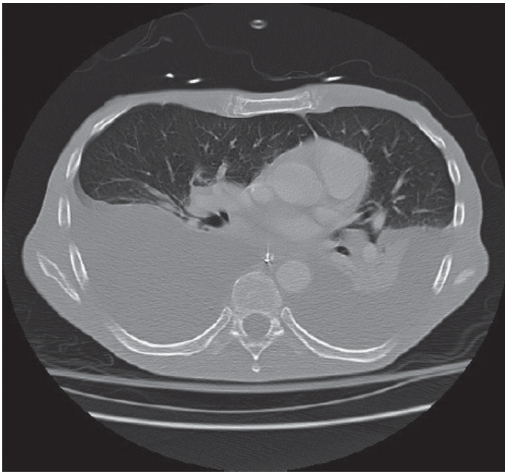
CT chest at the time of neutropenic fevers. Large bilateral pleural effusions without overt parenchymal infiltrates.
